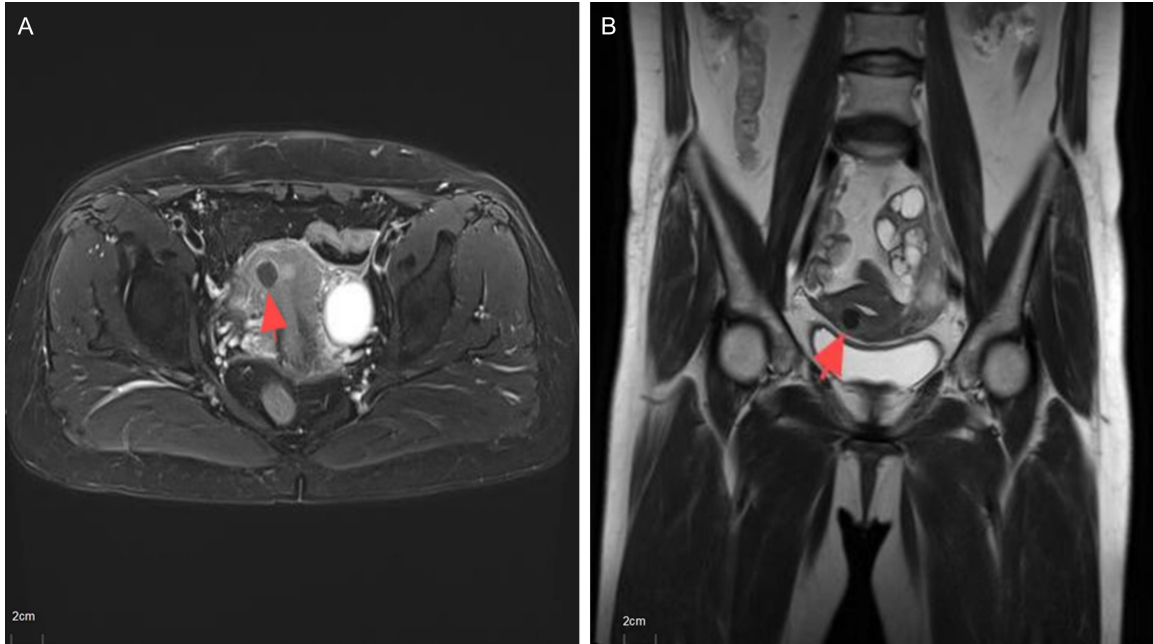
Imaging findings of uterine myolipoma with bizarre-nucleated cells. A: Axial view of plain pelvic MRI showing a well-demarcated heterogeneous signal mass in the anterior wall of the uterine corpus with adipose and soft tissue signal components (marked by red arrows); B: Sagittal view of pelvic MRI fat-suppressed sequence showing suppressed fat signals in the uterine mass, confirming that the lesion contains adipose and smooth muscle tissue components, consistent with the typical imaging characteristics of uterine myolipoma (marked by red arrows).
